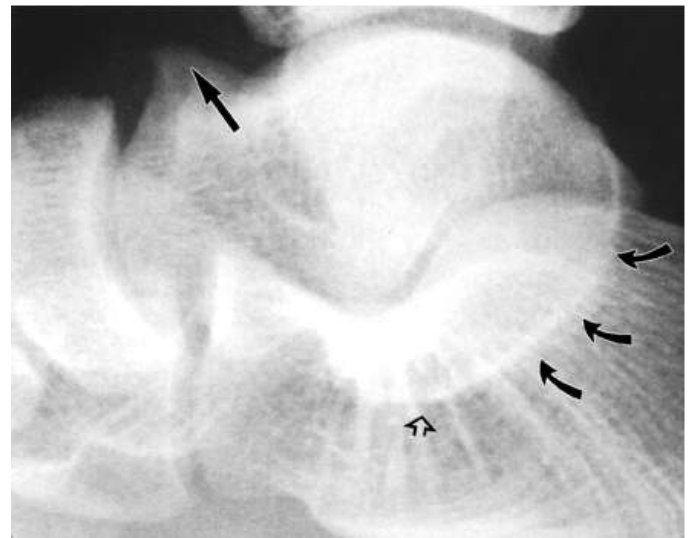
Lateral radiograph used to evaluate a tarsal coalition of a 25-year-old male. Talar beaking is demonstrated (solid straight arrow) as an upwards flaring of anterosuperior aspect of talar head. The C sign as demonstrated by the curved arrows, which is continuous cortical contour extending from medial aspect of talus to sustentaculum tali. The middle subtalar facet is not seen on this view. Note that sustentaculum tali shown as the open arrows, has a curved undersurface instead of a normal flat contour. The talar neck appears shorter than normal.
